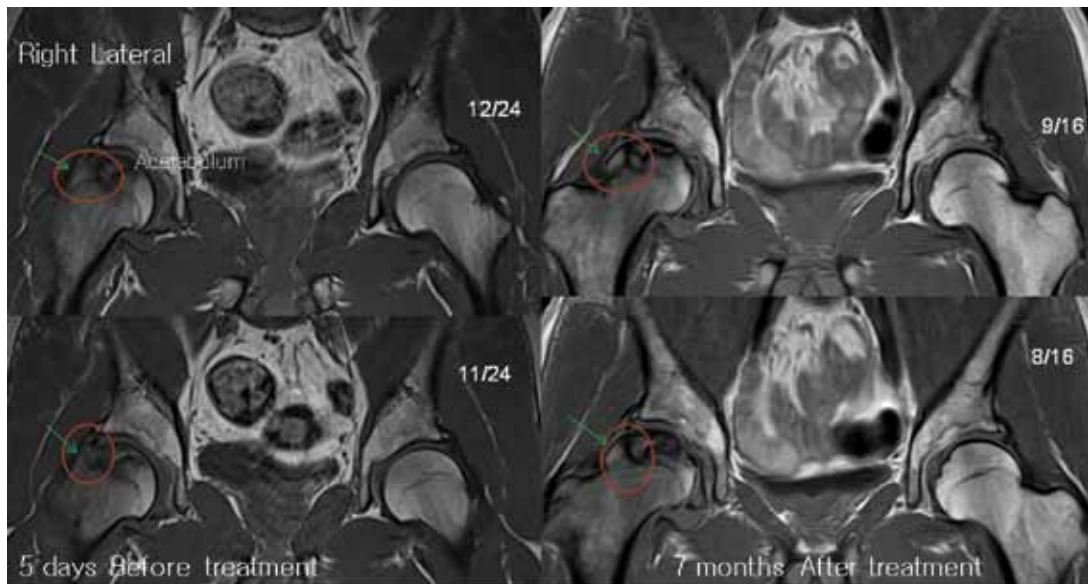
MRI results of Patient 2 (coronal views). T1 coronal sequential views showing apparent signal changes along the posterolateral injection site.
